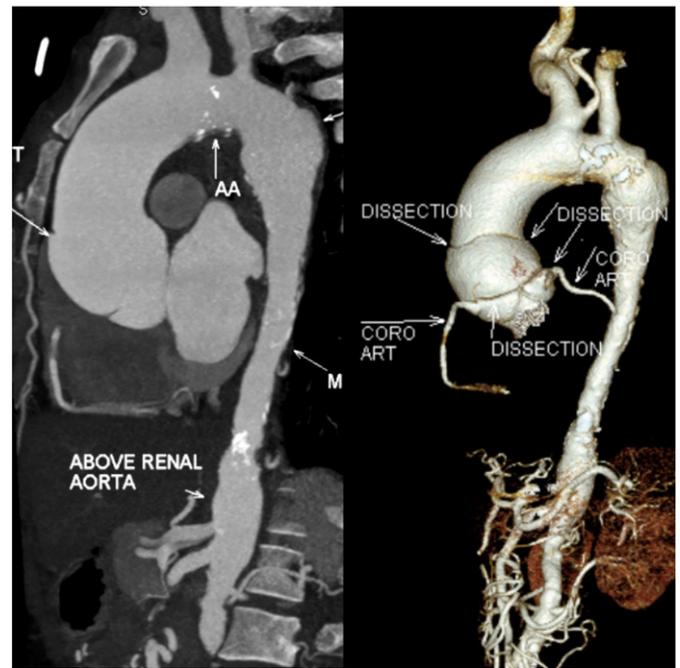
Pre-Op CT s/o Stanford type A aortic dissection.
